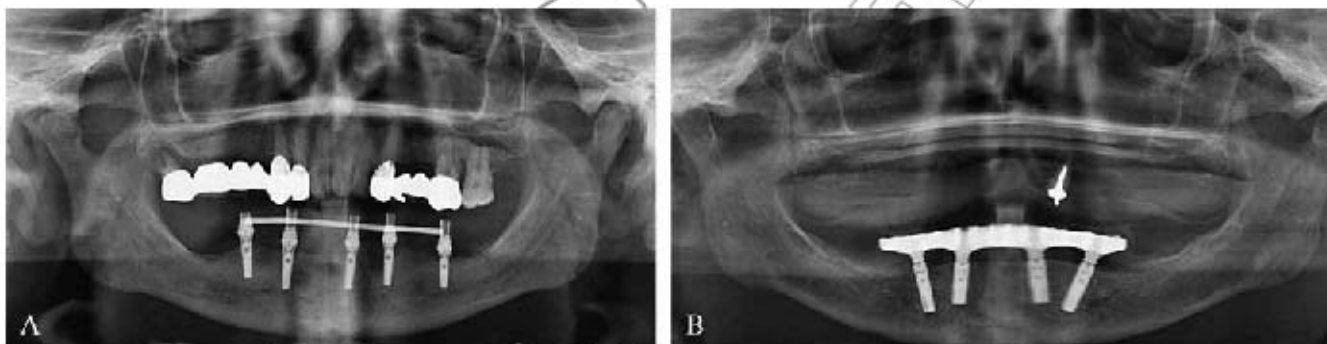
Panoramic radiograph for post-operative control taken immediately after surgery and at 3,6,12 months after surgery.
